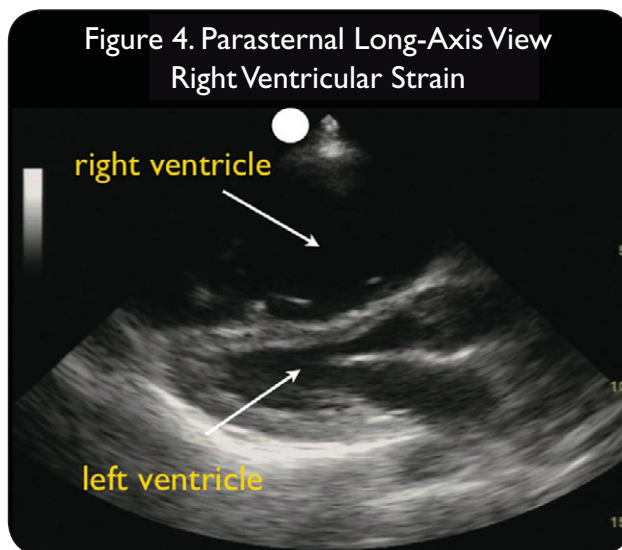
Parasternal Long-Axis View
